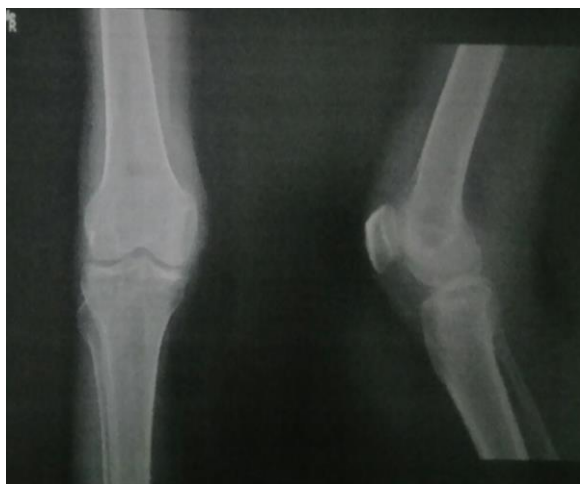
Pre procedure X-Ray
